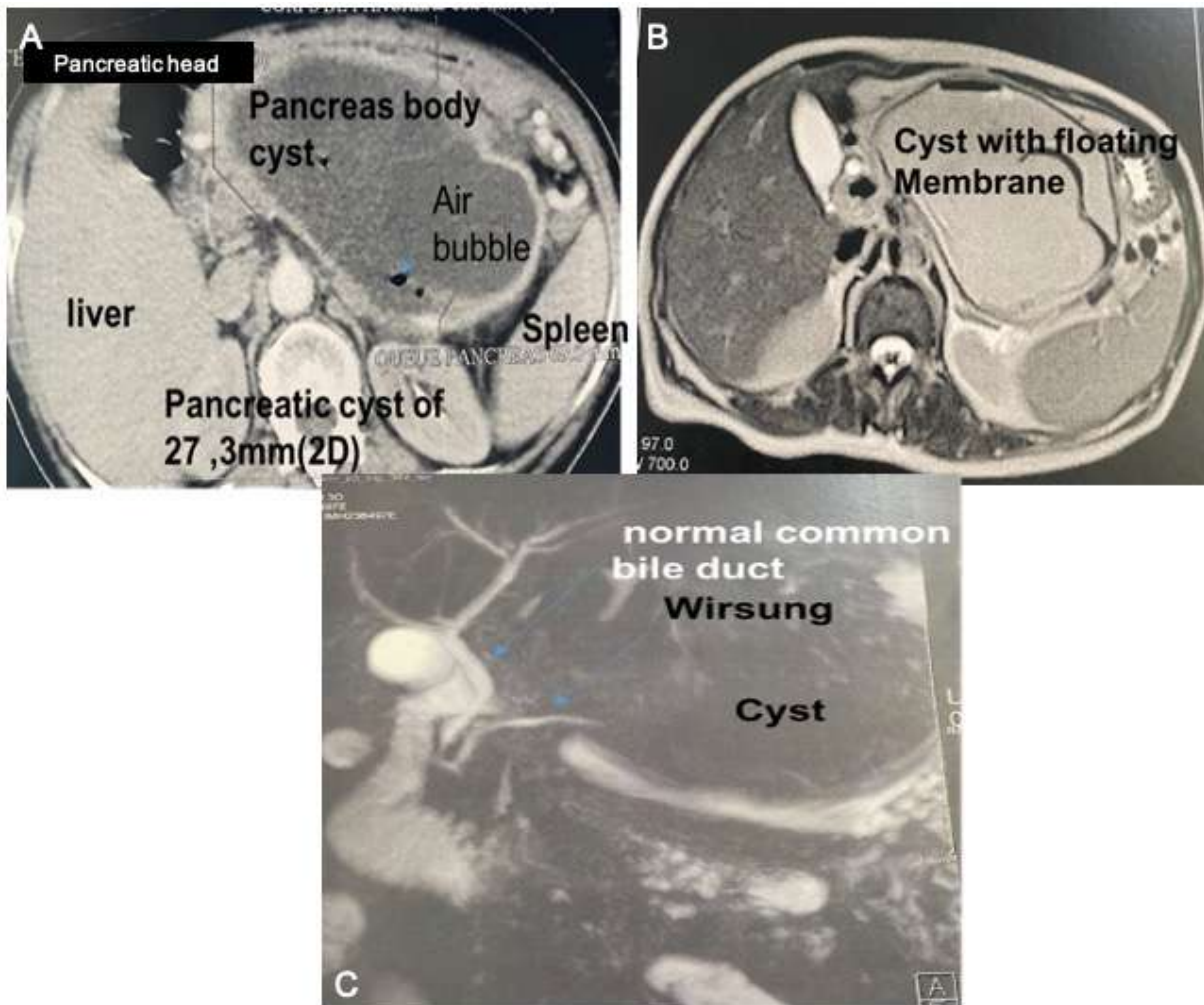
Axial image of apost contrast abdominal CT scan (A) showing a large cystic pancreatic mass of the body and tail of the pancreas containing some air bubbles with a thickened non enhanced wall. Image B: Axial MRI image in T2 weighted sequence showing a large cystic pancreatic mass with a floating membrane. Image C: Biliary-MRI showing a normal common bile duct and Wirsung non communicating with the large cyst.
